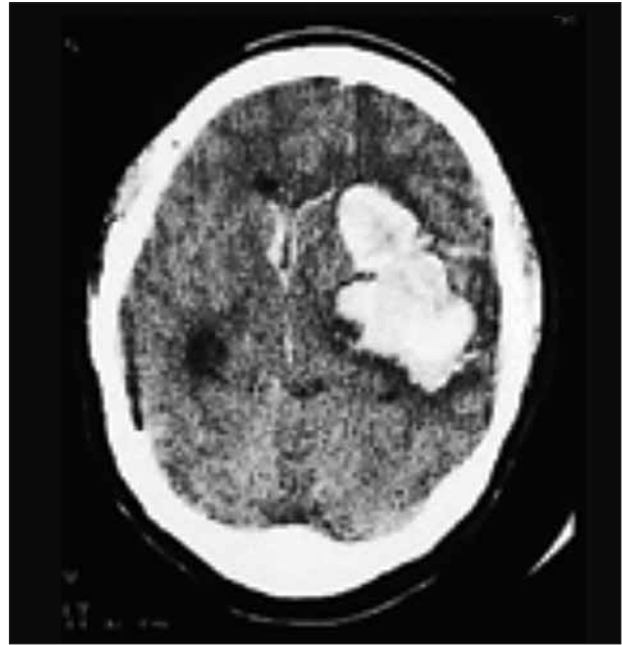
CT scan shows a frontal-parietal intraparenchymal haematoma.
